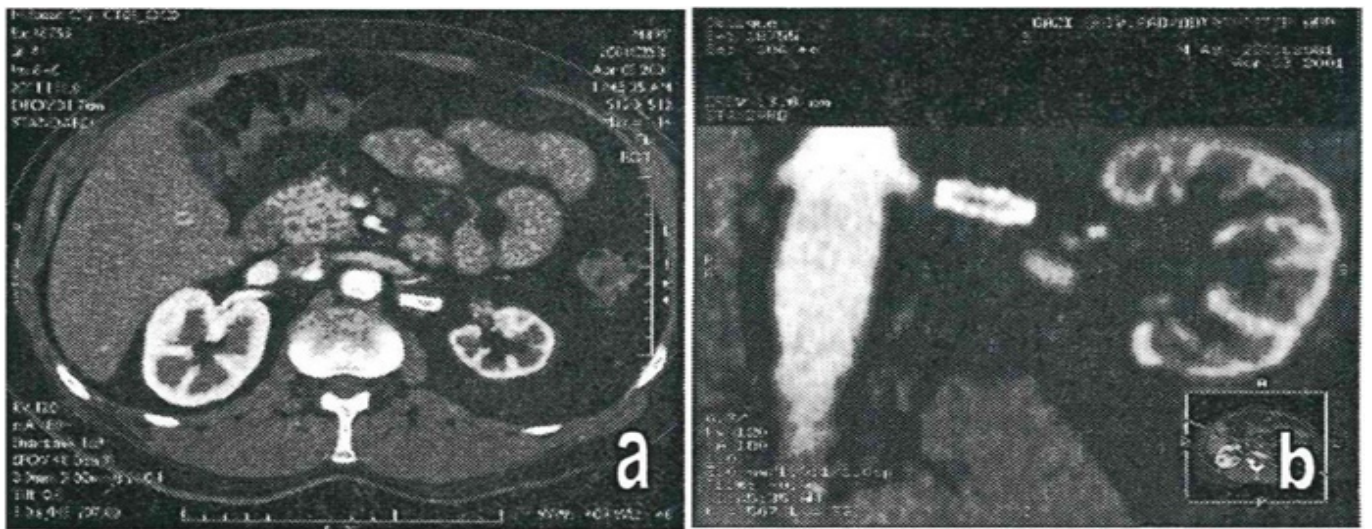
(a) In the same case, 4.5 years later, the spiral CTA follow-up shows a 1 mm reconstructed standard axial image obtained from volumetric data, and (b) a 0.7 mm thick MPR image in the coronal plane demonstrates a reduction in the size of the left kidney (long axis: 60 cm) and cortical thinning. Both kidneys are visible in the nephrograph phase
